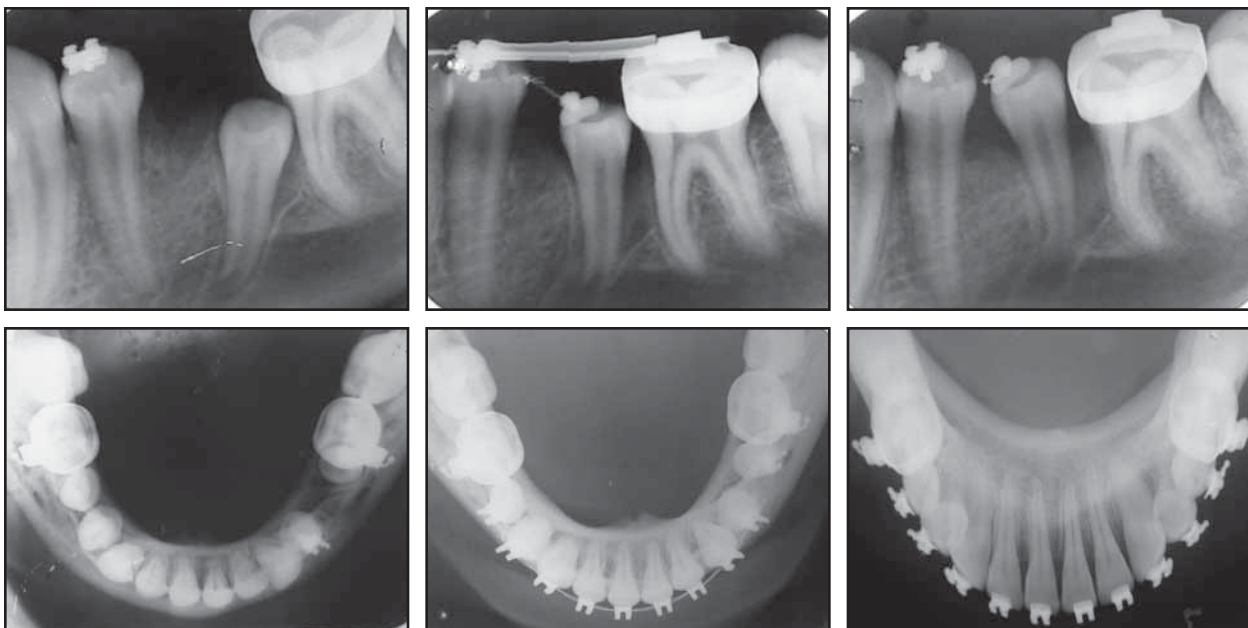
Serial periapical and occlusal radiographs after surgical exposure of mandibular left second premolar.
